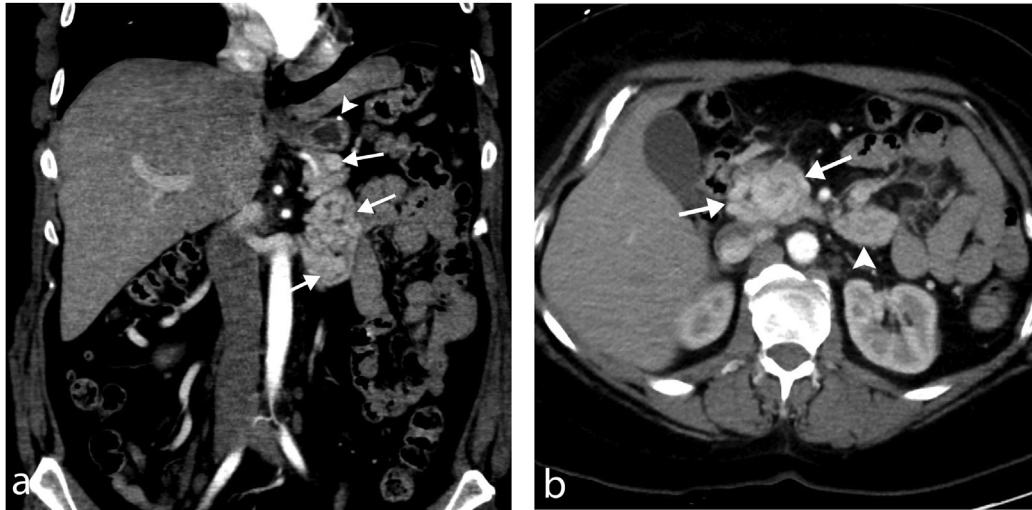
Coronal (A) and axial (B) images from CT of the abdomen and pelvis performed with intravenous contrast. Coronal image (A) shows numerous large varices throughout the distal third and fourth segments of the duodenum (arrows). Note surgical suture from sleeve gastrectomy (arrowhead). Axial image (B) shows large varices throughout the pancreatic head and second/third duodenal (arrows) and third/fourth duodenal segments (arrowhead).
